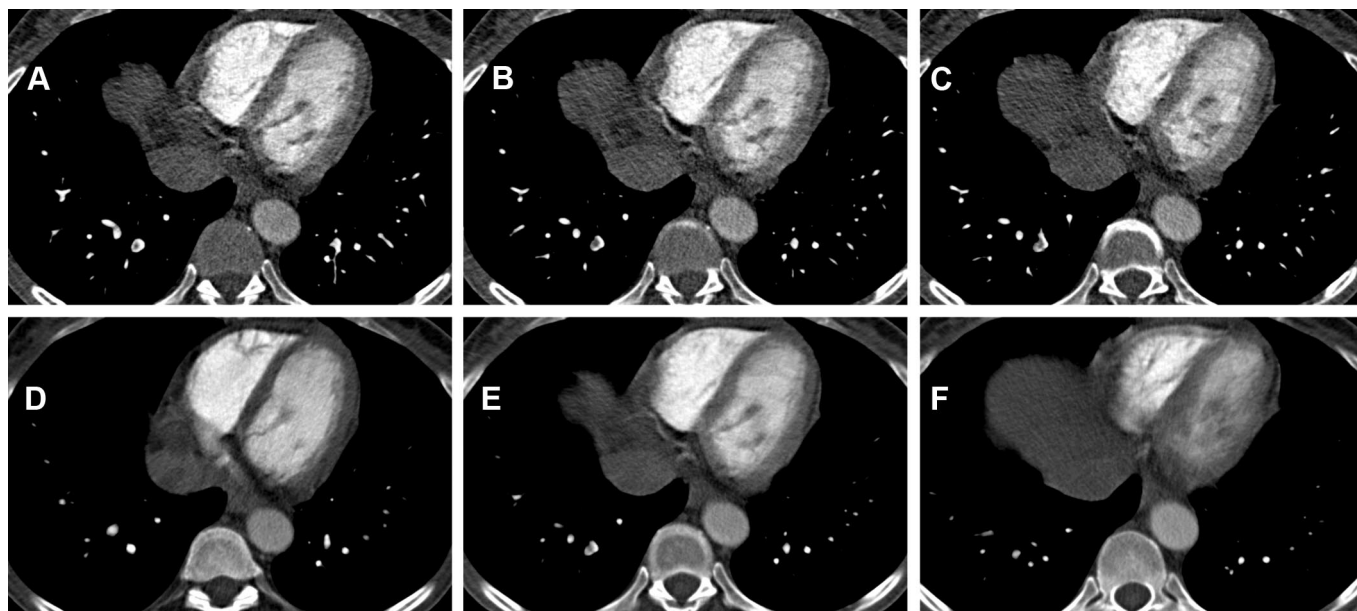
Radiographic images. A–C, Axial computed tomography (CT) images reconstructed at 1-mm thickness shows definite filling defects in two segmental pulmonary arteries in the right lower lobe pulmonary artery, which extended over consecutive axial images and met the diagnostic criteria for a diagnosis of pulmonary emboli (PE). D–F, Axial consecutive images of a routine restaging CT thorax at 5-mm thickness (same scan, same level, same window parameters as in A–C above) shows a subtle nonspecific filling defect in a segmental right lower lobe pulmonary artery, seen only on one slice (B), which did not meet diagnostic criteria for PE. The patient was completely asymptomatic at the time of scanning.
